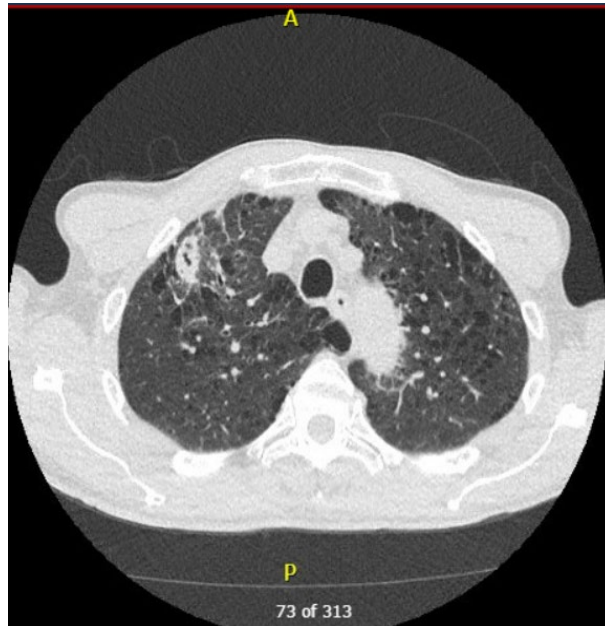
Low-dose screening CT chest shows a 2 cm right apical nodule with cavitation, with a background of emphysema and mild fibrosis.
